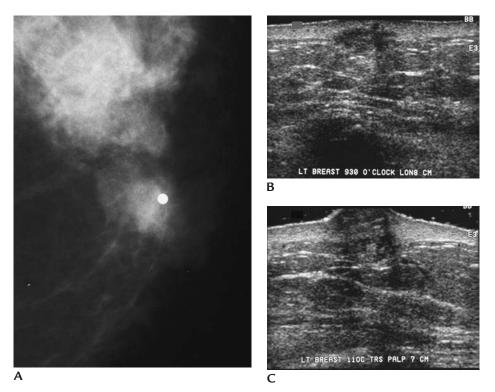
Cutaneous angiosarcoma. (A) Spot tangential view of one of three superficial palpable masses in the left breast demonstrating a round mass with indistinct margins (metallic BB used to denote clinical finding). (B) Oval, hypoechoic mass arising in the dermis and extending into the subcutaneous tissue is imaged sonographically corresponding to one of three palpable, violaceous masses involving the skin in a patient with a history of prior radiation therapy for breast cancer. The margins are not circumscribed and demonstrate some lobulation. (C) Oval hypoechoic mass arising in dermis corresponding to second of three palpable, violaceous masses involving the skin in a patient with a history of prior radiation therapy for breast cancer. There is associated expansion of the skin with a resultant, clinically apparent bulging contour. The margins of the mass are not circumscribed and there is associated shadowing.
